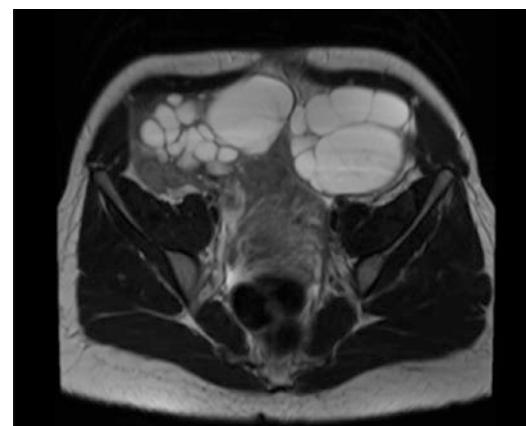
Theca lutein cysts in complete molar pregnancy on MRI (upper) and ultrasound (lower). Photos courtesy of Meaghan Tenney, MD
